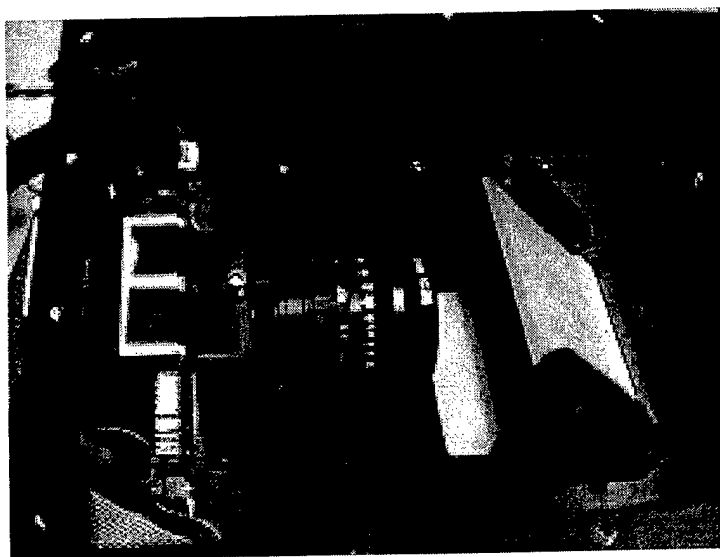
Photograph of mirror reflective prototype imager used to acquire x-ray images.
